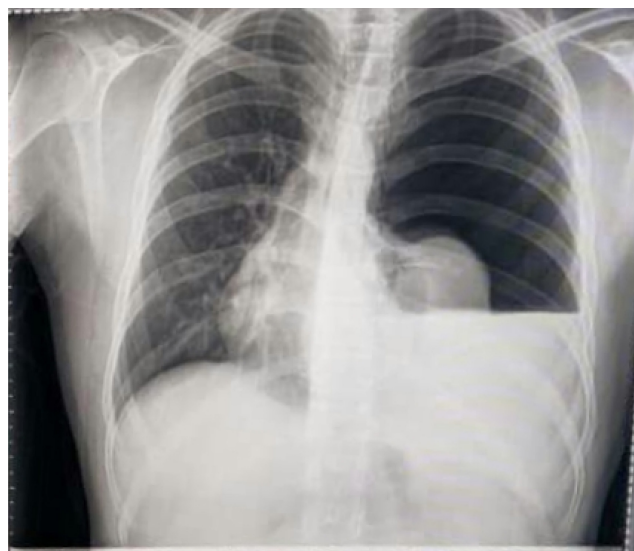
Chest X-Ray of the patient at come shows complete pneumothorax with air-liquid level in the left hemithorax.
